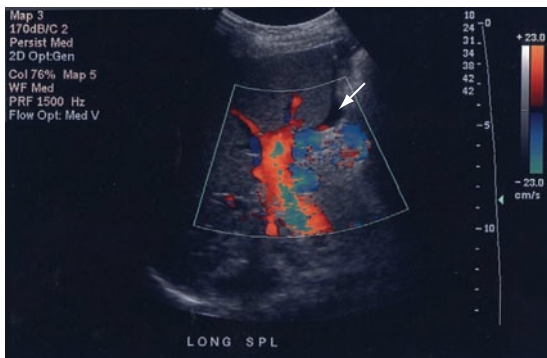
Vessels mimicking fluid. Color Doppler confirms anechoic structure to be a splenic vessels. However, a small anechoic area (arrow) without Doppler flow is seen under the spleen. This represents a minimal amount of free fluid.
